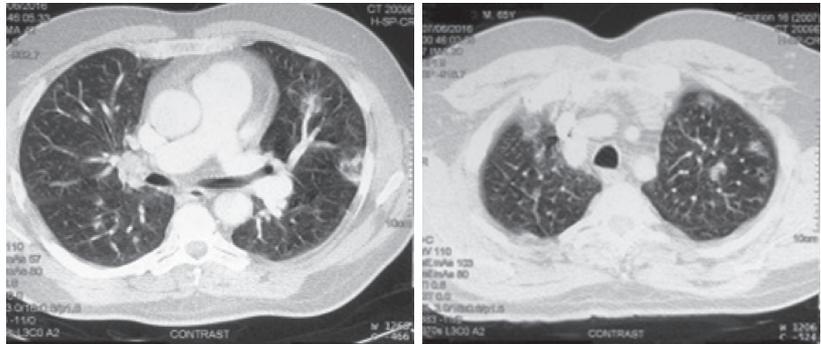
CT-pulmonary angiography revealed multiple wedge-shaped densities and nodular lesions with and without cavitation.
